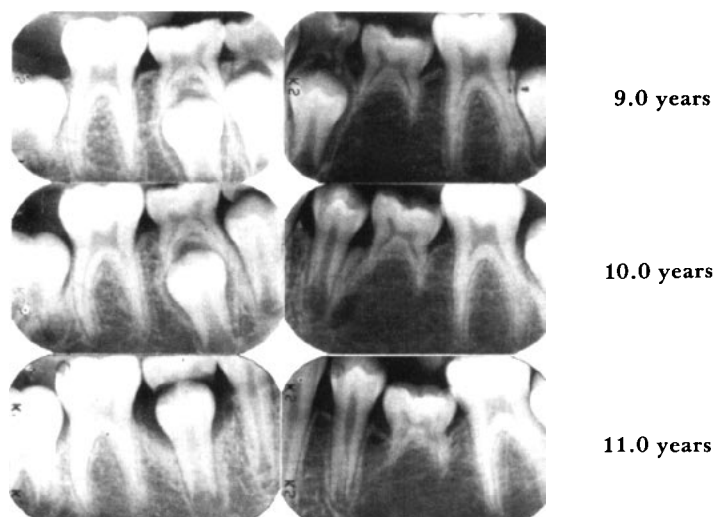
Periapical radiographs of a girl from 9.0yr to 11.0yr, when the infraoccluded deciduous molar with no successor was extracted and orthodontic treatment started. On the side with no successor, infraocclusion progressed from 4.0mm to 4.8mm, while on the side with a successor the lesser infraocclusion of 2.2mm was static. Note the tipping of the permanent molar, concave marginal alveolar bone contour and deciduous root resorption on the side with no successor.
